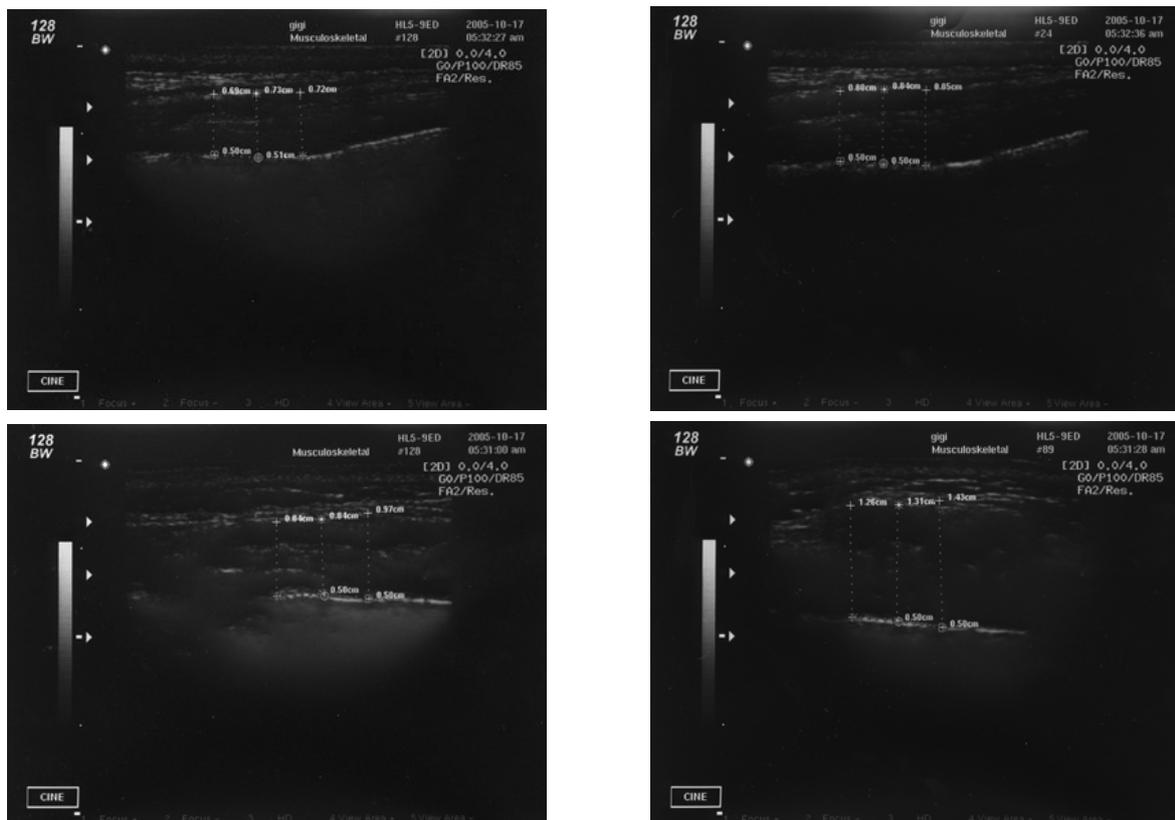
Ultrasonographic images (upper left, anterior temporalis (Ta) in a relaxed condition; upper right, Ta in a clenching condition; lower left masseter (Ms) at relax; and lower right Ms at clenching)
